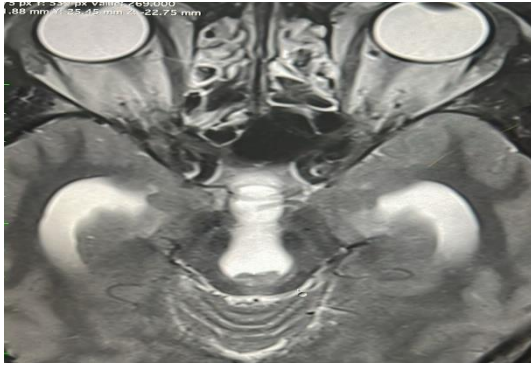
MRI of the brain demonstrates a well-defined lesion at posterior aspect of third ventricle which appears hypointense on T1, causing blockage of aqueduct of sylvius leading to upstream dilatation of both lateral and third ventricles.
